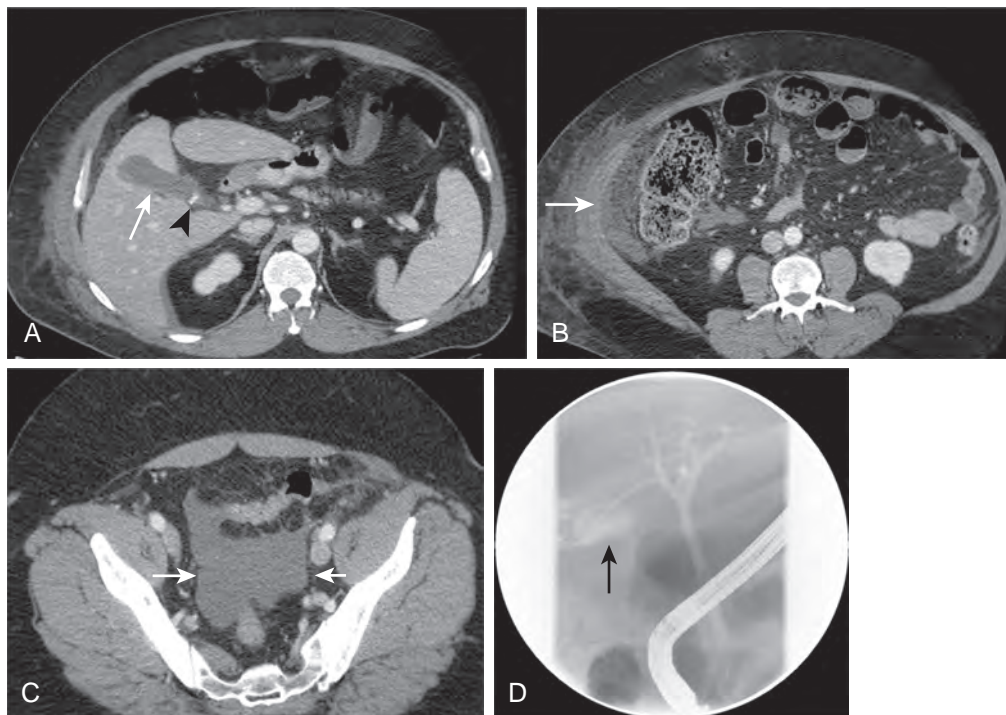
Bile leakage resulting in a biloma, biliary ascites, and peritonitis. A. CT 6 days after LC shows an oval fluid collection, a biloma, in the gallbladder fossa (arrow) adjacent to a surgical clip (arrowhead). The leaking bile assumes a pear-shaped configuration resembling the gallbladder. There is some free fluid in Morison's pouch. B. Inflammatory changes induced by leaking bile seen as marked omental infiltration (arrow), displacing the ascending colon medially. C. Large amount of fluid in pelvis (arrows); its clear density, although nonspecific, is compatible with bile. D. Subsequent ERCP shows active extravasation of contrast material, probably from the cystic duct remnant (arrow).
